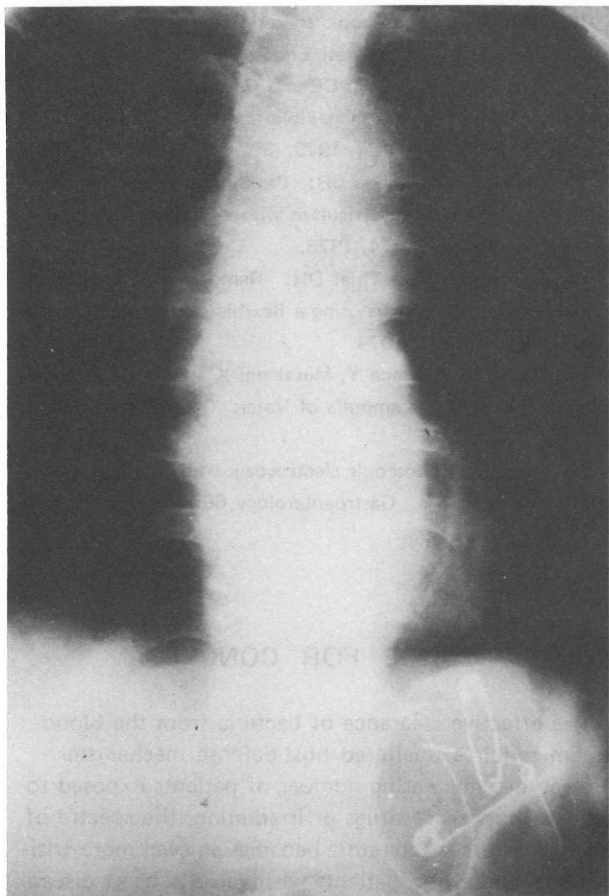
Radiograph showing two pins in the stomach.
